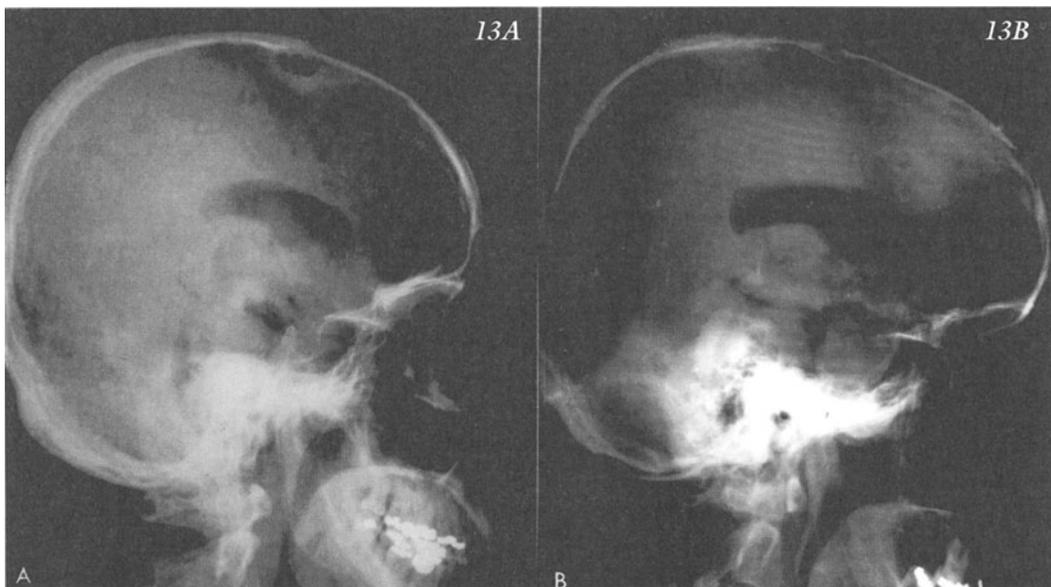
Pneumoencephalogram: A large pituitary adenoma has ballooned out the sella turcica on the X-ray. With the injection of air, via a lumbar puncture the extrasellar extension may be seen. A. Normal; B. Abnormal. (Courtesy of Dr. Samuel Wolpert, New England Center Hospitals)
